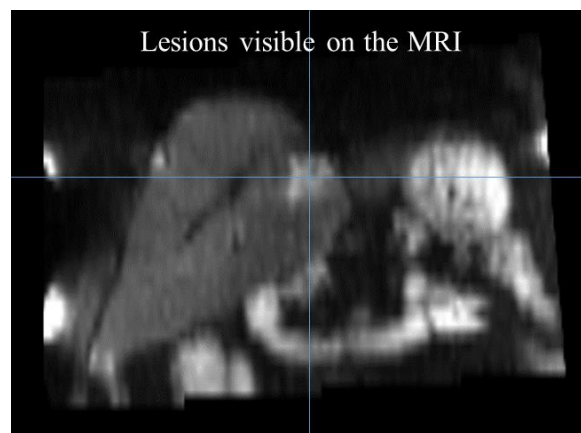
Lesions visible on the diagnostic MRI used as a support for uptake volume definition.
